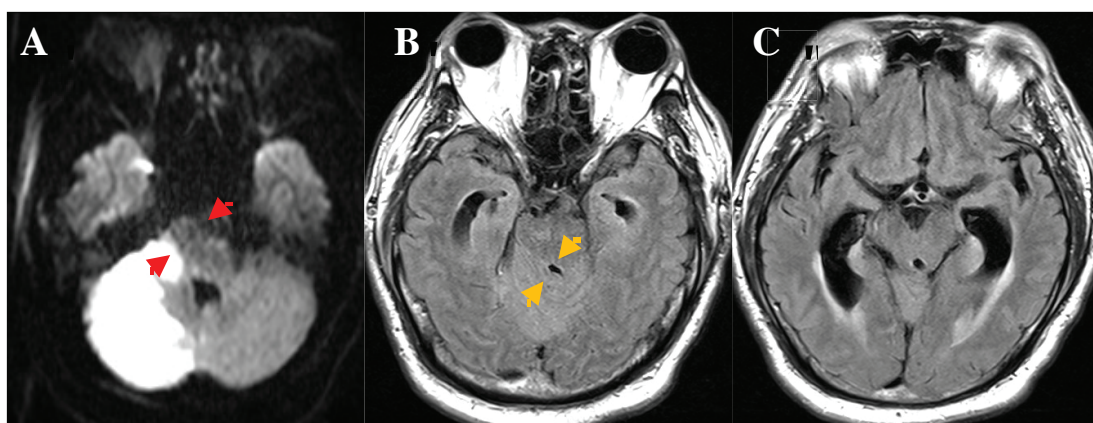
Diffusion-weighted imaging (DWI) showing brainstem compression between the thrombosed aneurysm and worsening edema of the cerebellar infarction (A) (red arrow). Fluid attenuated inversion recovery (FLAIR) images (B). (C) showing obstructive hydrocephalus because the fourth ventricle was entrapped between the thrombosed aneurysm and a worsening edema caused by right cerebellar infarction (yellow arrow).
